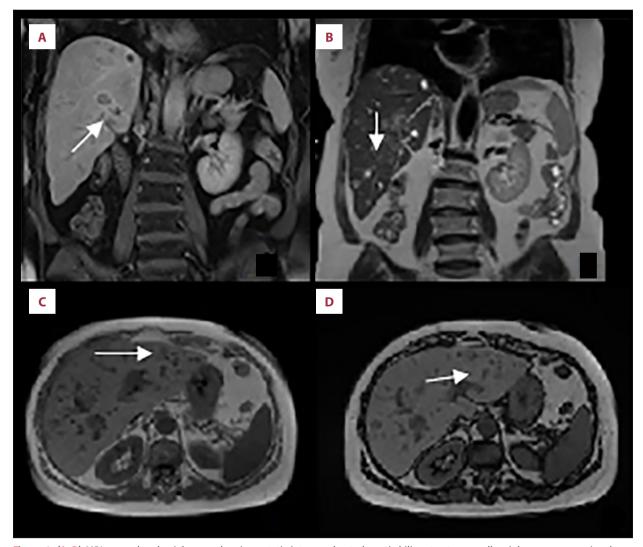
(A–D) MRI coronal and axial scans showing ectatic intra- and extrahepatic biliary tracts, as well as inhomogeneous signal intensity due to the presence of multiple centimetric nodular areas partly confluent (arrows).
